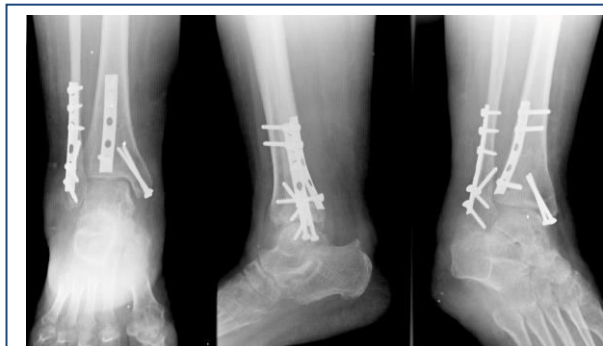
Follow-up X-rays.
